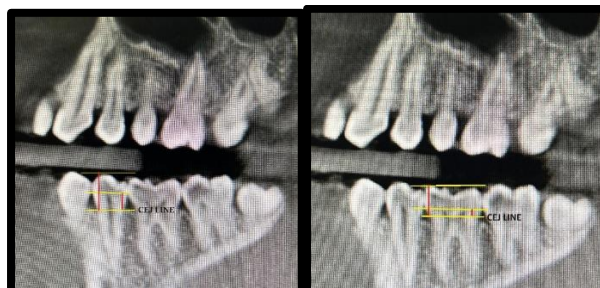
a) Sagittal section of CBCT with measurements on mandibular second
